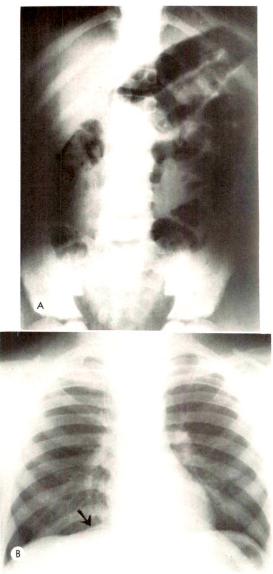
(A) A supine roentgenogram of the abdomen shows a fairly large coprolith in the right lower quadrant. (Courtesy of Drs. Charles Walkoff and Albert Salzman.) (B) An erect posteroanterior chest roentgenogram of the same patient demonstrates free air beneath the right hemidiaphragm. The pneumoperitoneum was secondary to a perforated appendix associated with a coprolith.
